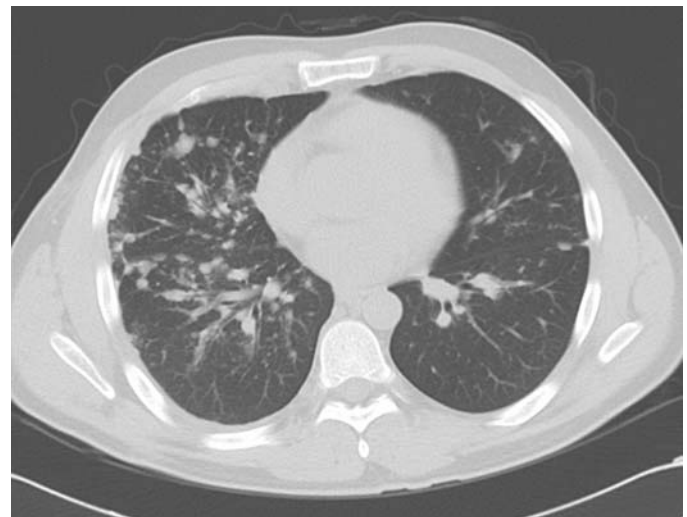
FIGURE e24-22 Sarcoid—CT scan of stage II (nodular opacities tracking along bronchovascular bundles).
